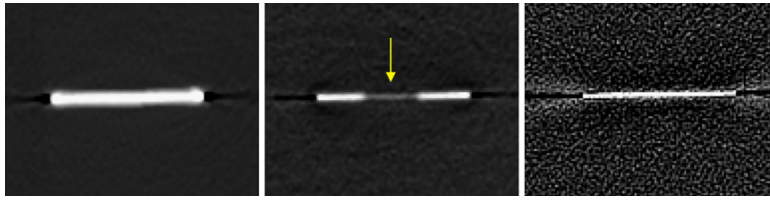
CT-image slice of a copper disc. CHU with MAR (left), EHU with MAR (middle), where a yellow arrow indicates effects due to MAR, and EHU without MAR (right).
